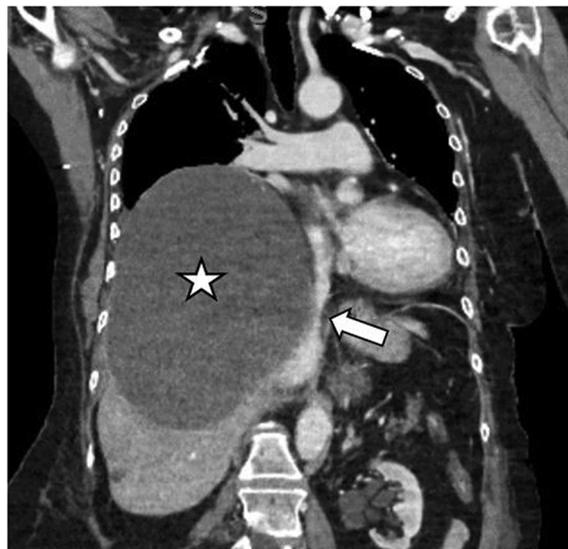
Coronal contrast enhanced CT scan demonstrating massive hepatic cyst (star) causing compression of the superior vena cava (arrow).
